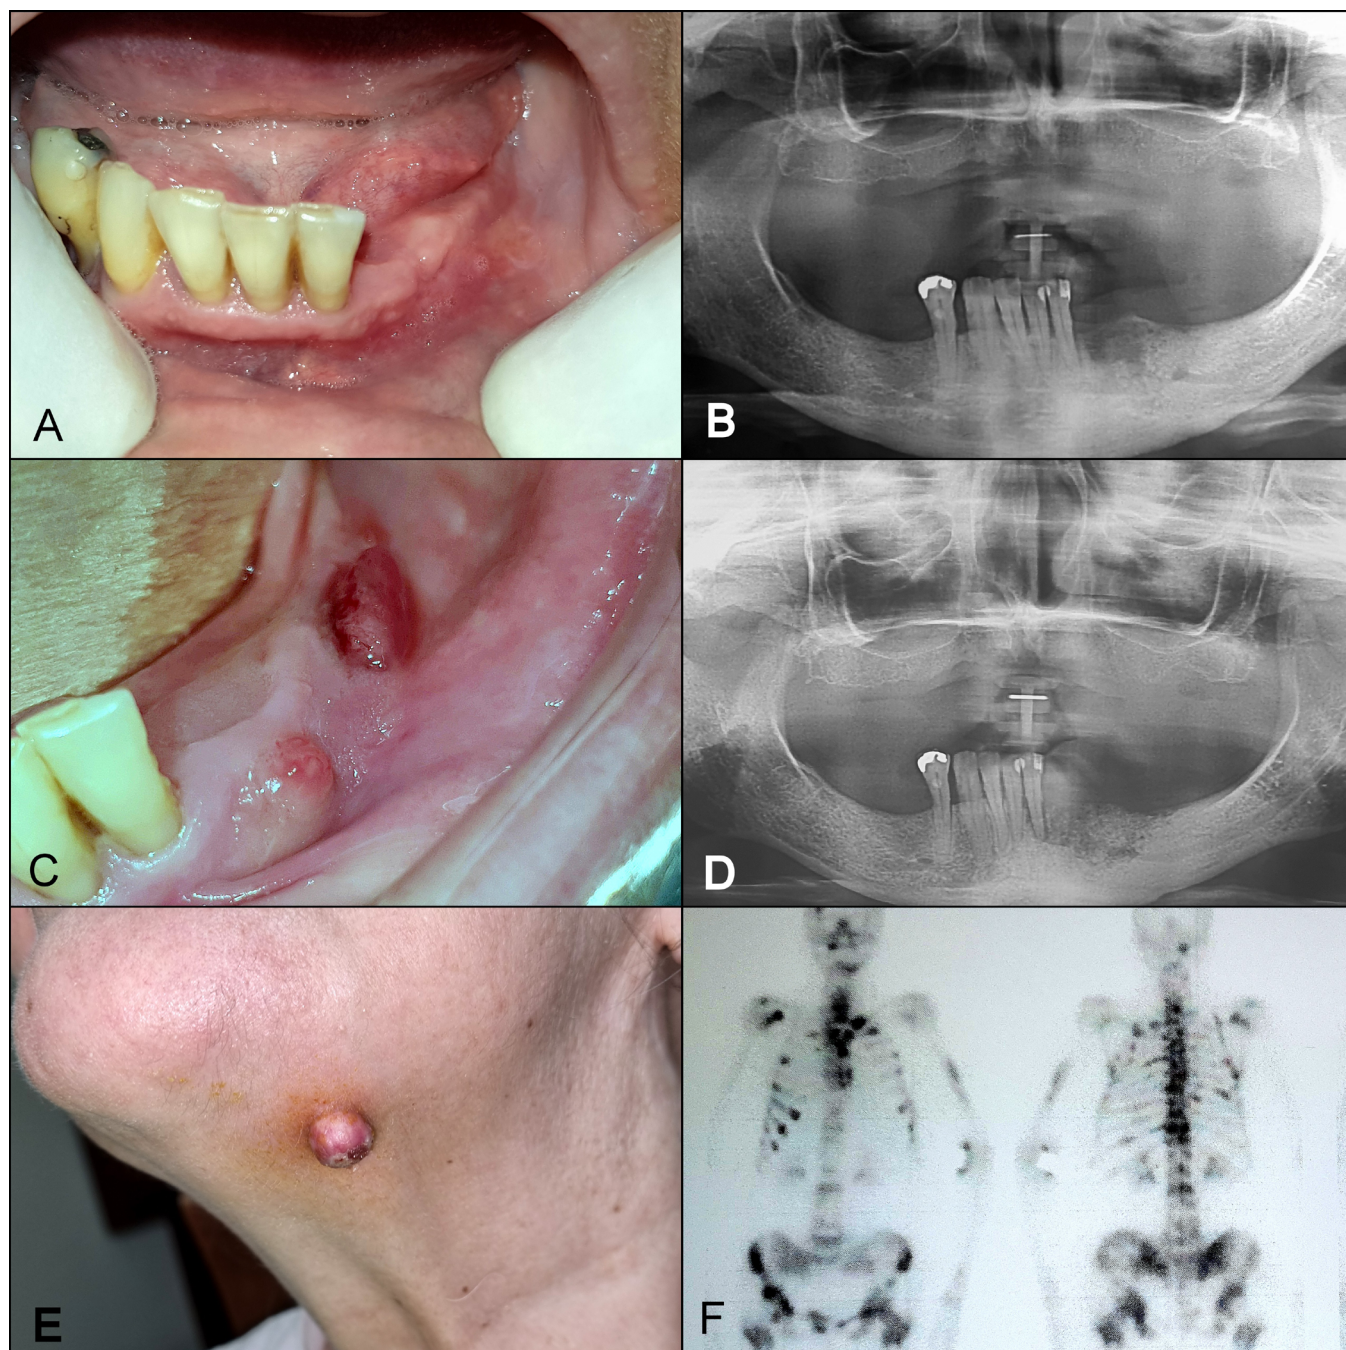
72-year-old woman treated for 3 years with Zoledronate for breast cancer before the start of the Sars-Cov 2 pandemic with MRONJ stage 0. (A) She presented a slight increase in volume in the left jaw and absence of suppuration after a tooth extraction. (B) In the panoramic radiograph, an osteolytic lesion could be observed in the area adjacent to the lower lateral incisor. The patient was diagnosed with MRONJ Stage 0. (C) During admission to our service, the patient showed a Vitamin D3 dosage of 24 ng/ml. Antibiotic treatment was indicated but no intervention could be made due to the lockdown and quarantine due to the pandemic. She was monitored only 8 months later with an aggressive evolution of the disease. Multiple fistulas were observed accompanied by two bleeding lesions with active, very painful purulent discharge. (D) The radiographic analysis revealed an increase in mandibular osteolysis, with a pattern of moth-eaten bone involving adjacent teeth (which were clinically mobile). A diagnosis of MRONJ in Stage 3 was reached. (E) Infectious oral-cutaneous fistula associated with necrotic focus of the jaw. (F) A scintigram during the oncological follow-up showed new metastatic lesions in the clavicles, lower limbs, ribs, and skull. The vitamin D3 dosage was 18 ng/ml. The patient reported an absence of sun exposure during 8 months of isolation. The patient died 3 months after the last follow-up due to multisystem failure associated with her underlying oncological metastatic disease.
